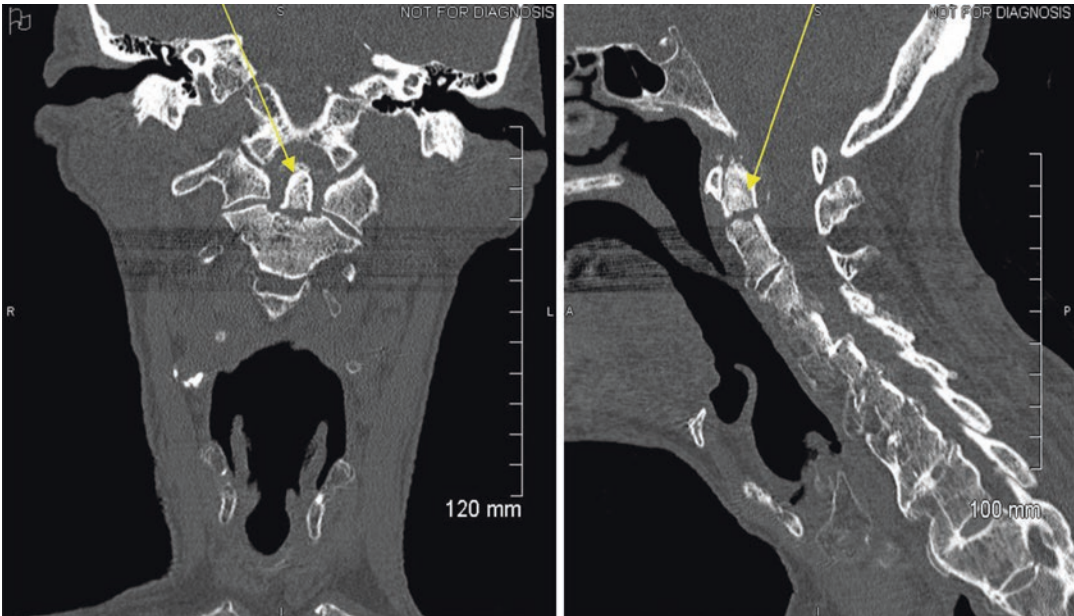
Pseudarthrosis of odontoid process (CT scan of cervical spine in coronal and sagittal sections): not detected after a significant trauma 4 years earlier
